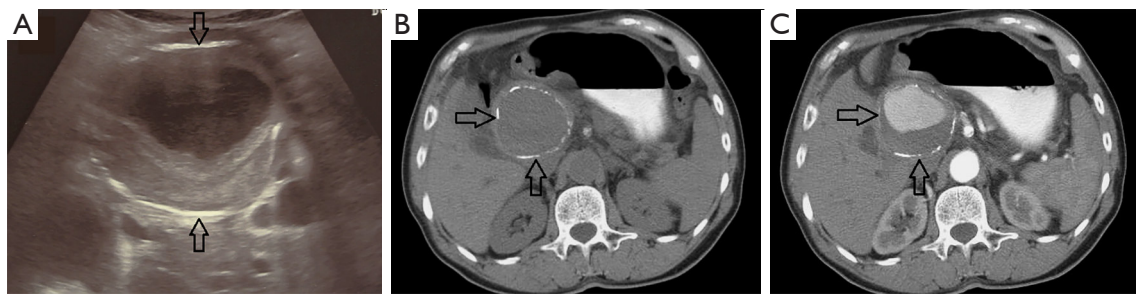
(A) Abdominal ultrasound demonstrating hypoechoic mass with hyperechoic wall (arrows) at the hilum of the liver; (B) non-contrast CT of the liver confirmed the presence of cyst-appearing lesion with hyperdense wall (arrows) at the hepatic hilum; (C) contrast-enhanced CT demonstrating the lesion filling with contrast in arterial phase. CT, computed tomography.
